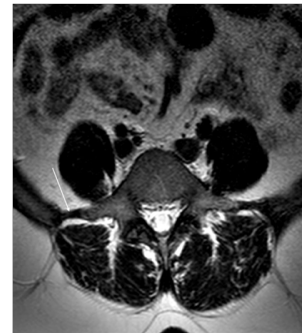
Axial T2-weighted MR image showing iliolumbar ligament on the left as a hypointense linear bands extending from transverse process to the posteromedial of the iliac crest.
